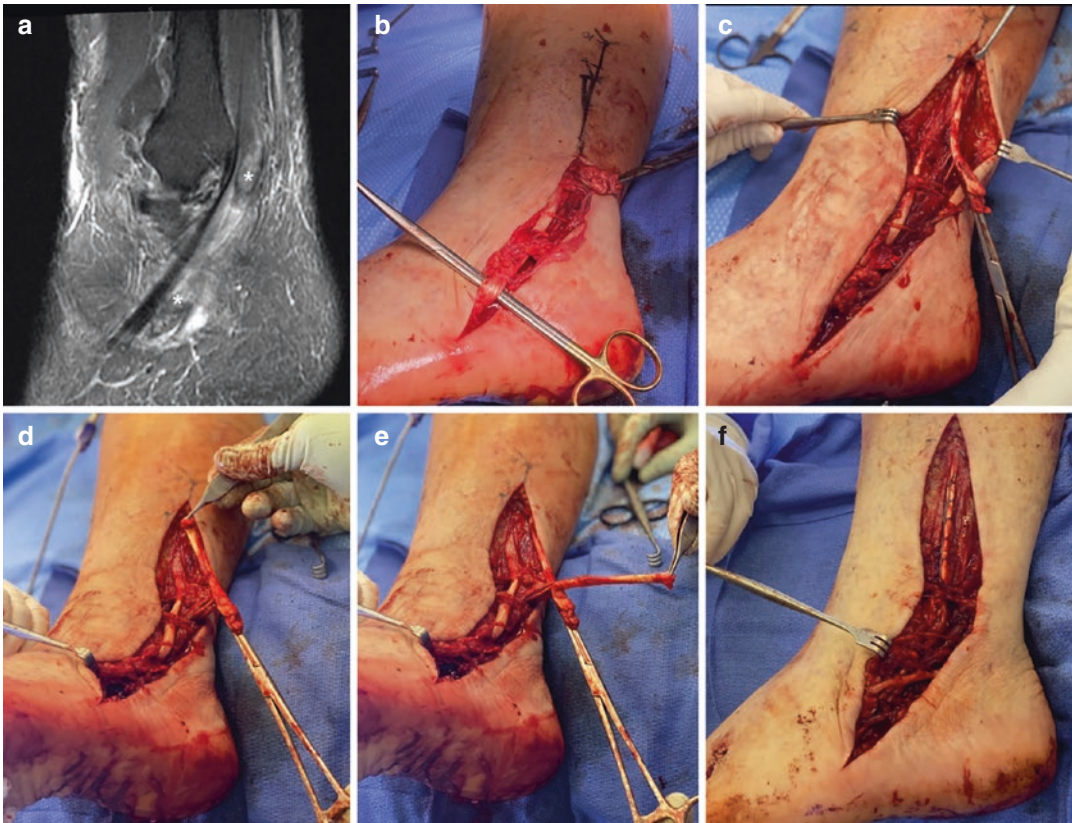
Peroneal tears and turndown repair. (a) A select sagittal MRI showing distal intrasubstance fibrillations of the peroneus brevis and completely torn peroneus longus with a large gap between the proximal and distal tendon stumps. (b) Surgical photo showing the intrasubstance tearing with preserved continuity of the frayed peroneus
